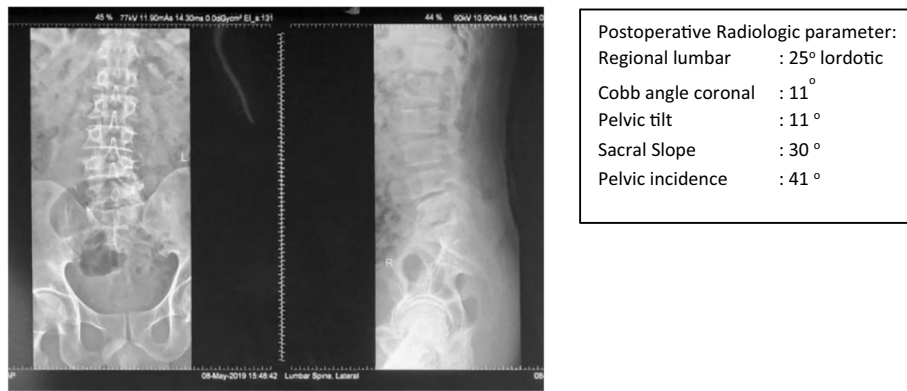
Case 4 postoperative radiograph.
